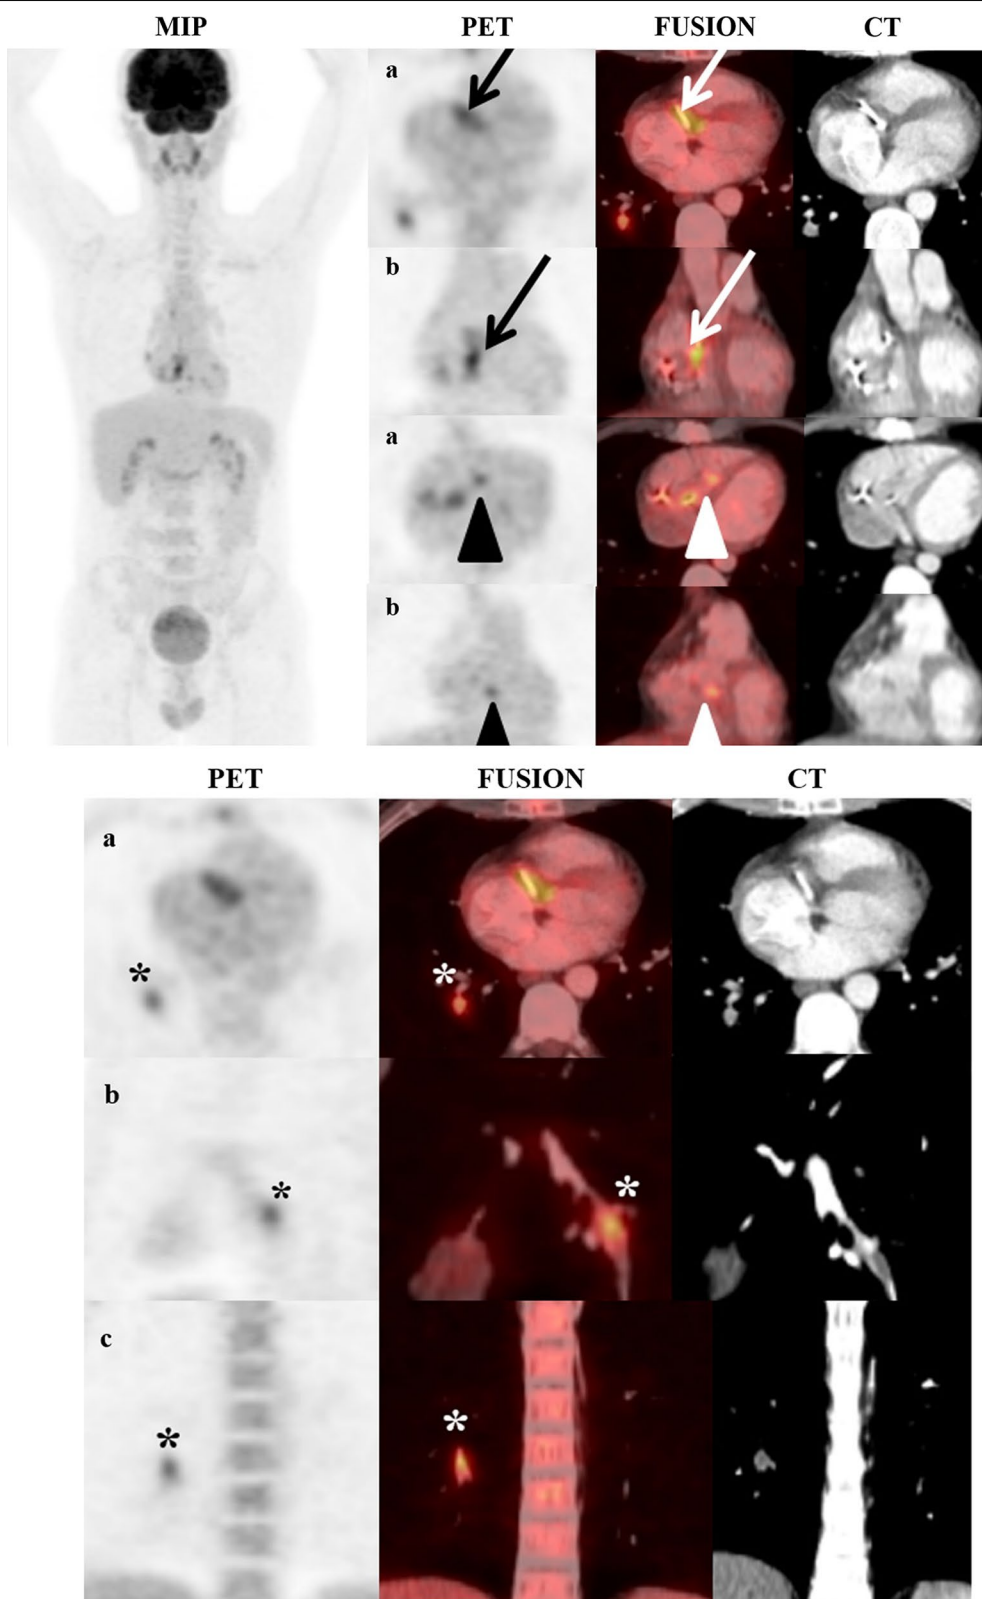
^{18}F FDG PET/CT images showing hypermetabolic lesions in the prosthetic tricuspid valve (arrows) and papillary muscle of the right ventricle (arrow heads). Beside these lesions, PET images revealed a less intensity focal FDG uptake in the pulmonary artery branch of the right lung lower lobe, which was consistent with septic pulmonary emboli (asterisk) (a axial plane, b: coronary plane). MIP: Maximum intensity projection.
